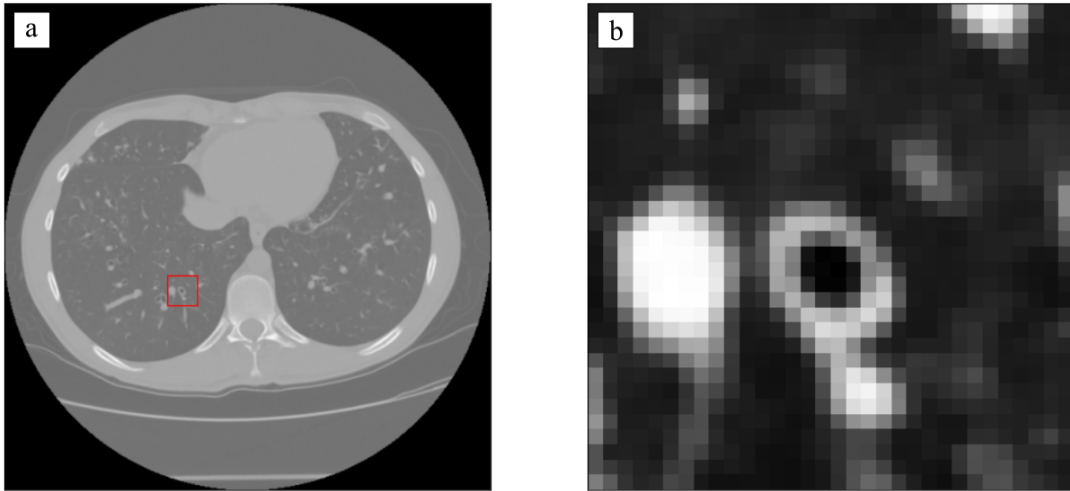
(a)* HRCT slice on which the ROI is highlighted with a red square. *(b)* The same region is shown as the final image used for the analysis.
